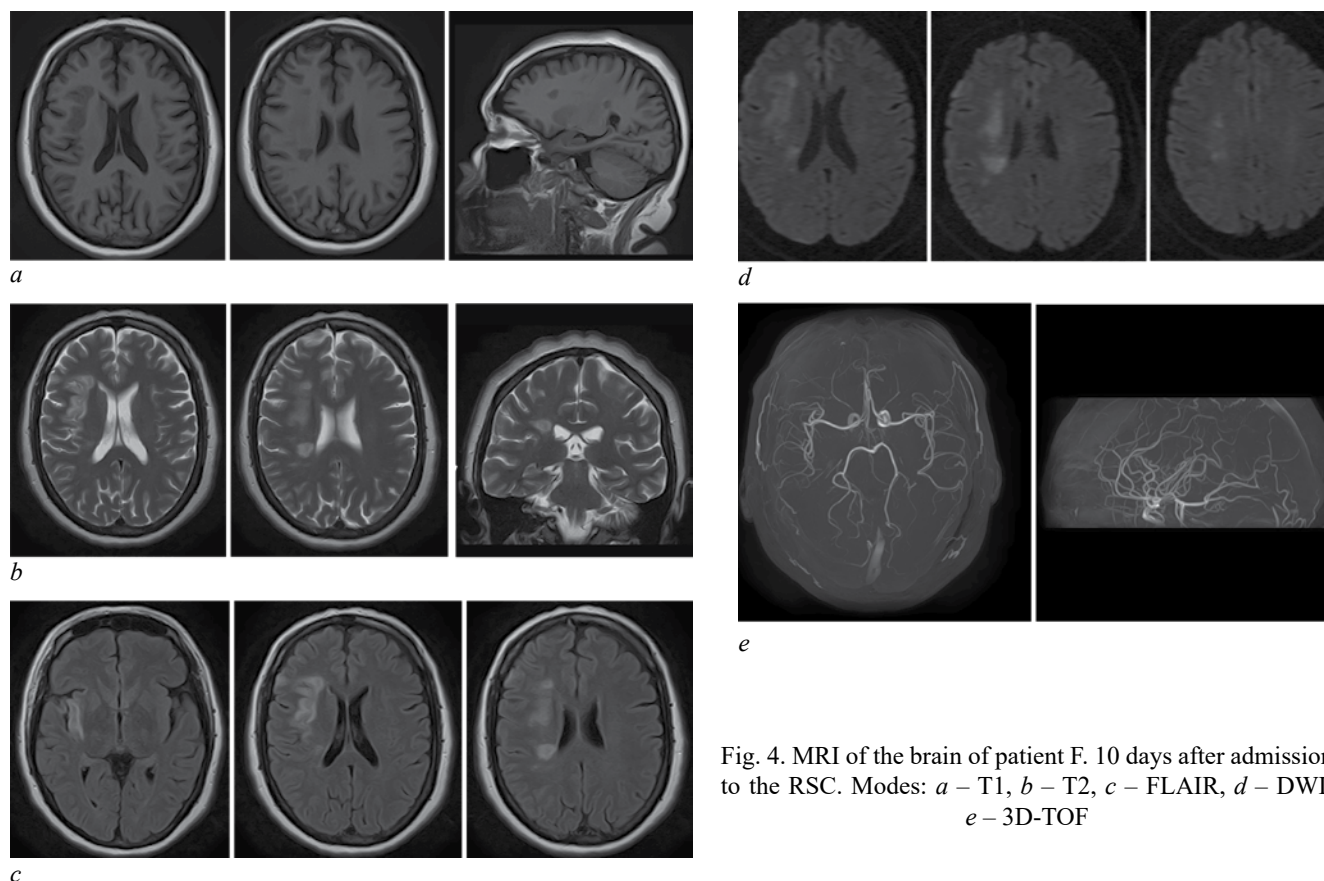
MRI of the brain of patient F. 10 days after admission to the RSC. Modes: *a* – T1, *b* – T2, *c* – FLAIR, *d* – DWI, *e* – 3D-TOF
